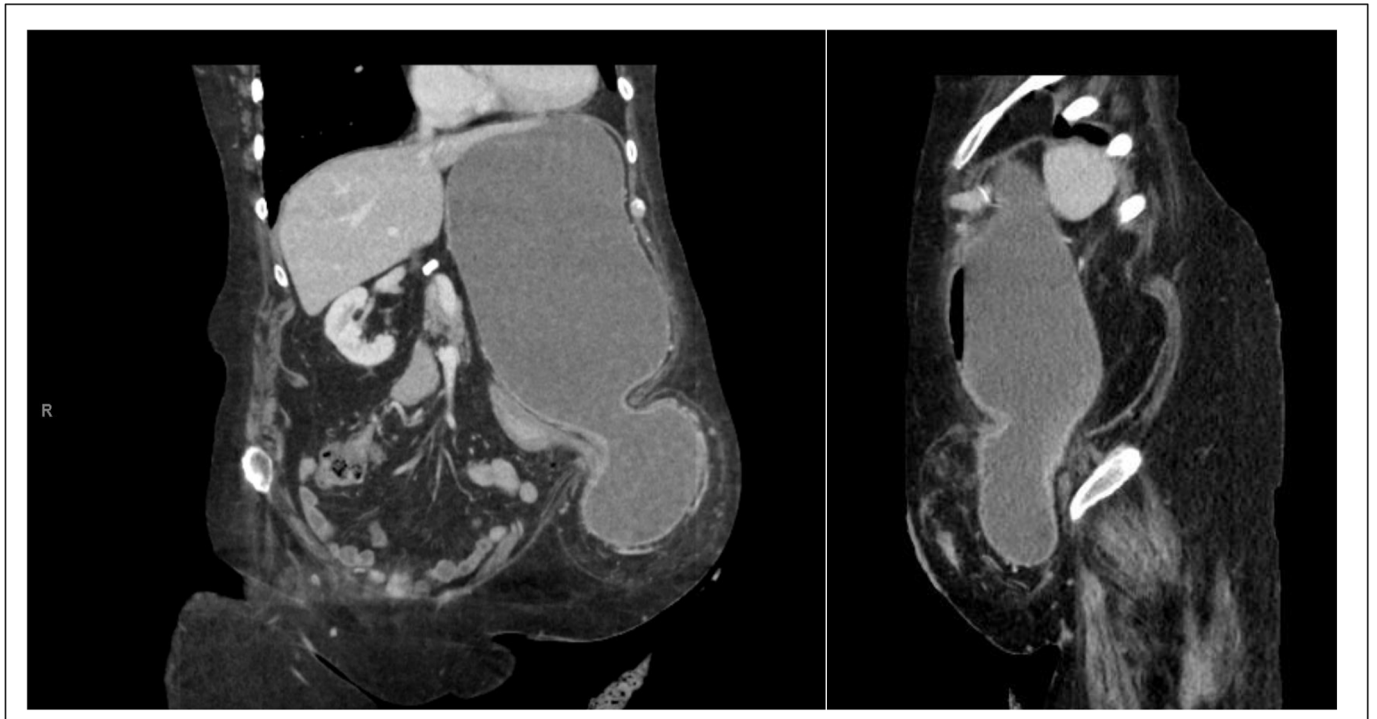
(Left) Coronal Computed Tomography view of stomach Herniating into left lower quadrant stoma. (Right) Sagittal Computed Tomography view of stomach Herniation into left lower quadrant stoma.
